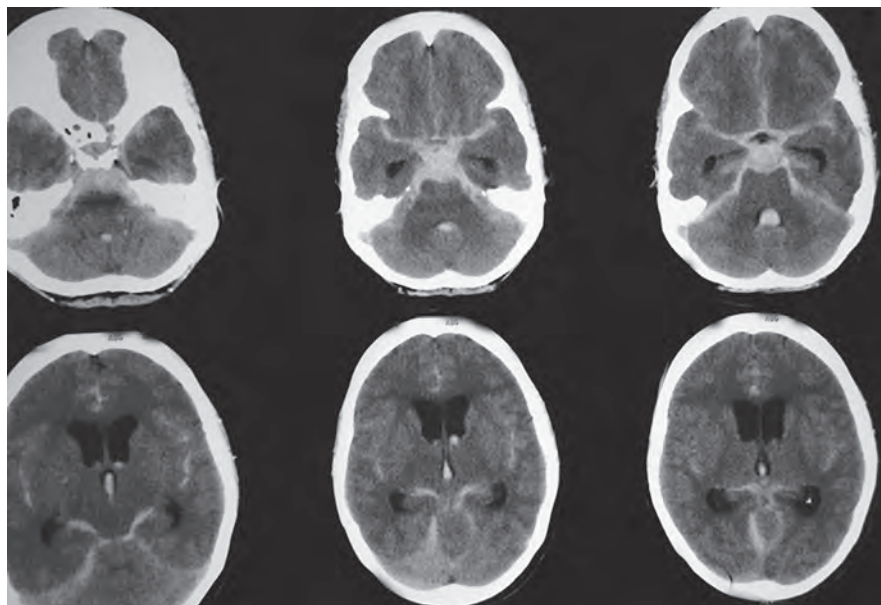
Computed tomography scan of brain showing extensive SAH
